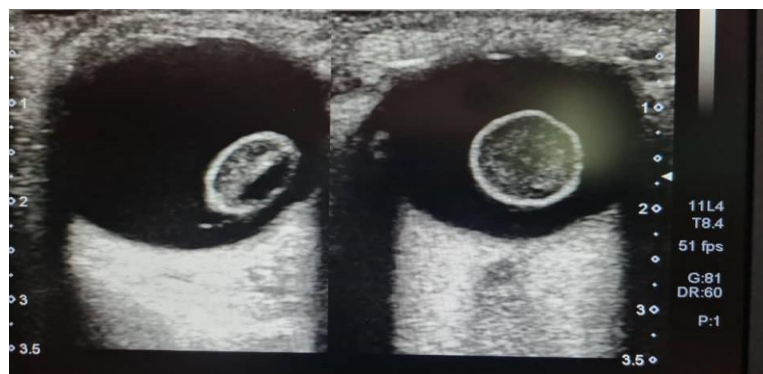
Ocular sonogram showing posteriorly dislocated and displaced lenses within each globes. The lenses also show thickened echogenic walls. Presence of low level internal echoes are noted within both vitreous compartments
